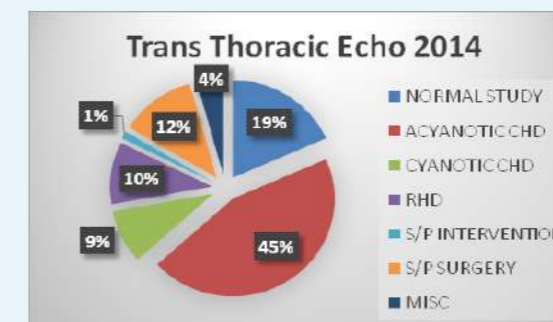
Echocardiography Findings
